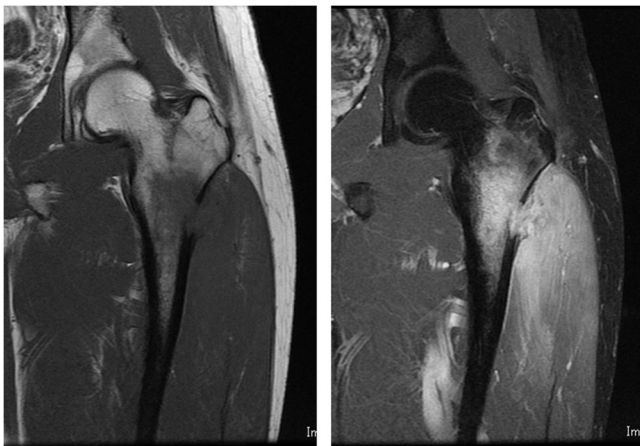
Magnetic resonance imaging of the left femur. T1-weighted (a) and T2-weighted (b) coronal images.
